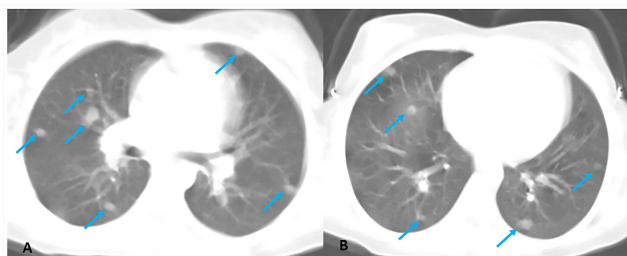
A & B: Contrast-enhanced chest CT (axial image) demonstrates multiple bilateral peribronchovascular and subpleural nodules, several with flame-like extensions (arrows)
